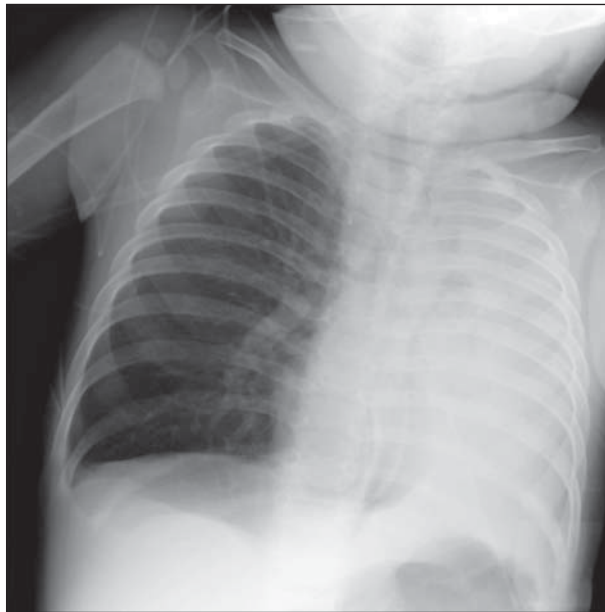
Chest radiograph demonstrates pneumomediastinum with subcutaneous emphysema. Additionally, there is near-complete collapse of the left lung with associated leftward mediastinal shift.
